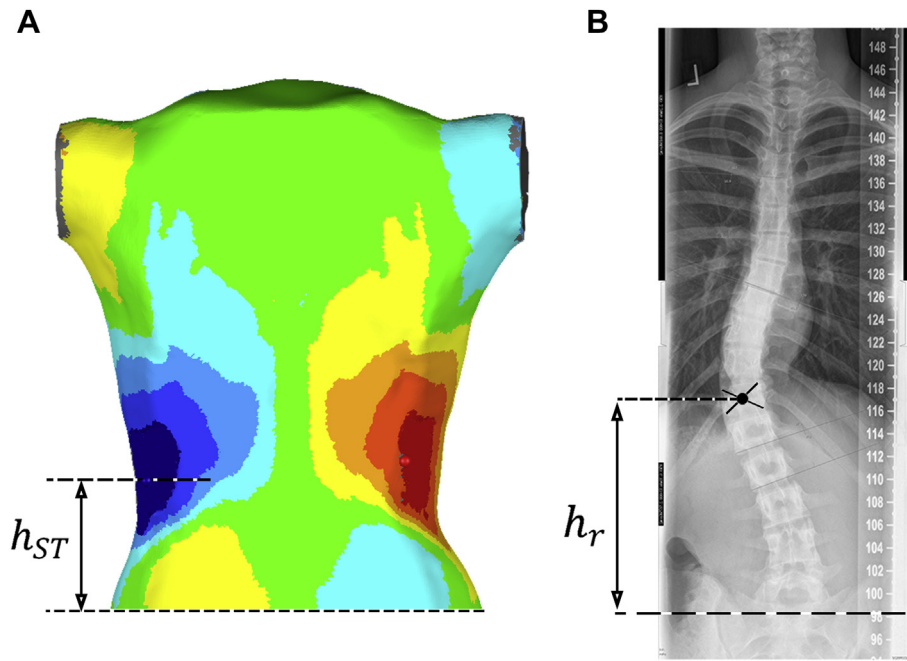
(A) Vertical distance between the point with maximum deviation and posterior superior iliac spine (PSIS) measured from the deviation color map. (B) vertical distance between apical vertebra and PSIS measured using corresponding radiograph.
